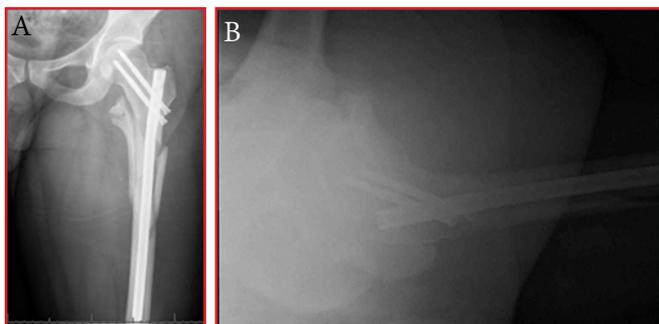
Intraoperative radiographs of the left femur, showing placement of the intramedullary nail at the greater-trochanteric entry site. A) Anteroposterior view. B) Lateral view.
